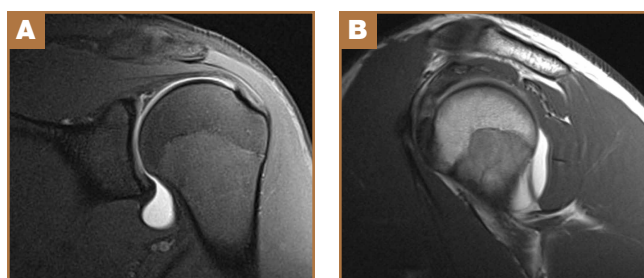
(A) Gadolinium-enhanced T1-weighted sagittal magnetic resonance arthrography (MRA) of left shoulder, which shows confluence of the long head of the biceps tendon (LHBT) and rotator cuff at the interval. Similar to MRA of right shoulder, note the absence of fluid surrounding the tendon. (B) Gadolinium-enhanced T2-weighted coronal MRA of left shoulder shows tear of the superior labrum.
